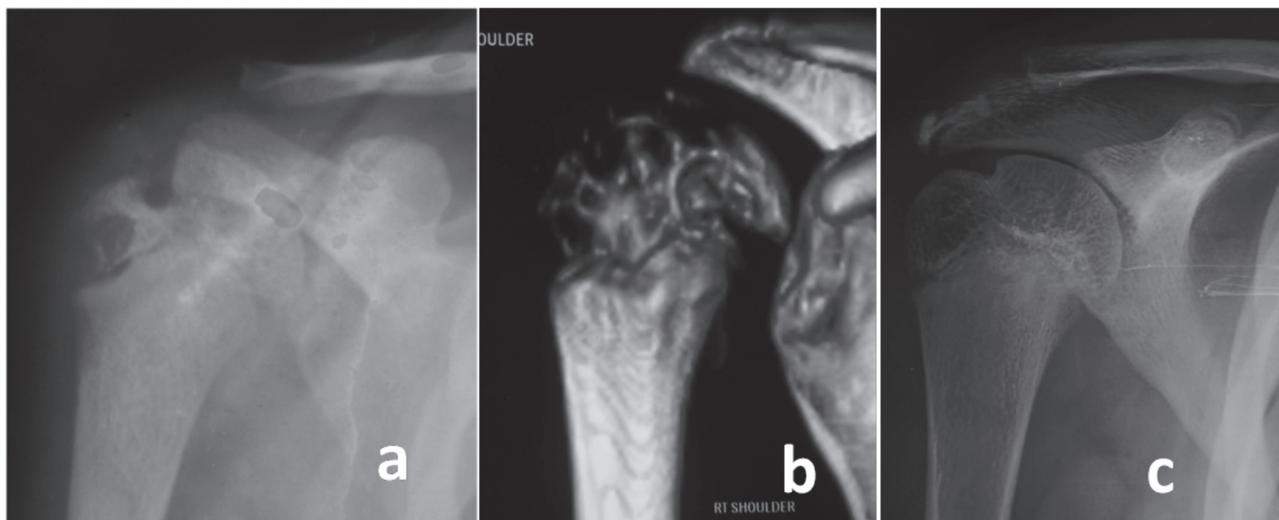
Localized epiphyseal lesion (a,b) Plain radiographs and CT of shoulder showing multiple lytic lesions involving whole of the epiphysis (c) Last follow up 5 years. Complete healing.
